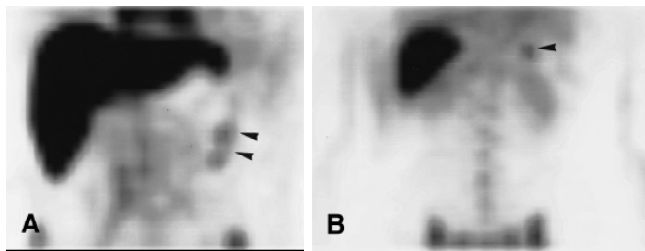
Postoperative denatured red blood cell scintigraphy in a young woman with a single accessory spleen detected on preoperative CT and removed during surgery. At 27 months postoperatively, DRBCS demonstrated three foci of residual splenic tissue (arrow). Two foci are located in the left flank (A) and one in the splenic bed (B) overlying the left kidney. The patient had recurrent thrombocytopenia 21 months postoperatively.
